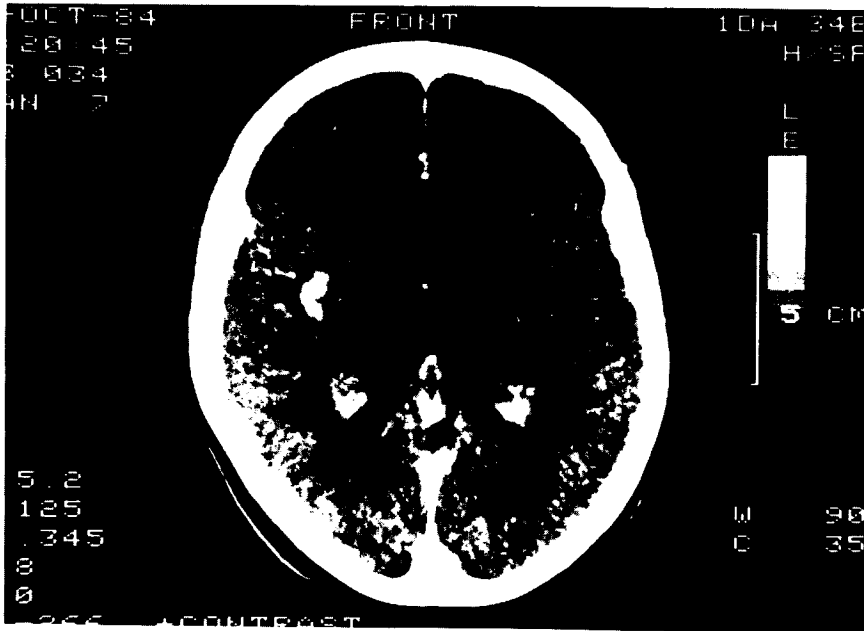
CT scan repeated 7 days after Figure 1, with contrast. The hypodense area shows contrast enhancement confirming it as a recent infarct.
